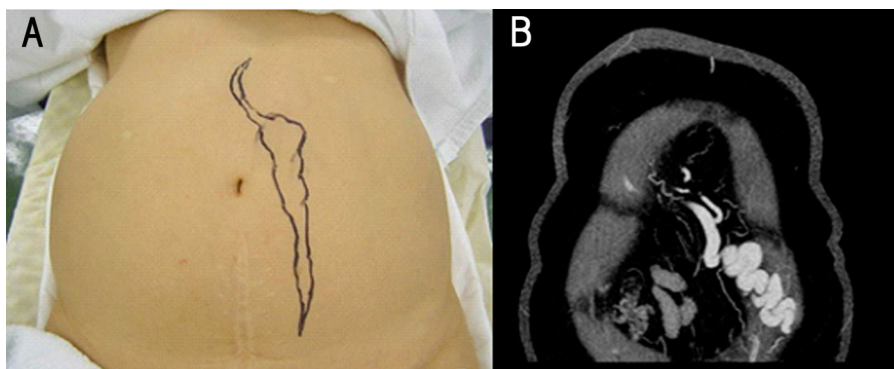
(A) Dilated subcutaneous collateral veins are marked preoperatively using ultrasonography. (B) CT scan shows a dilated subcutaneous vessel connecting with the ligamentum teres hepatis.
